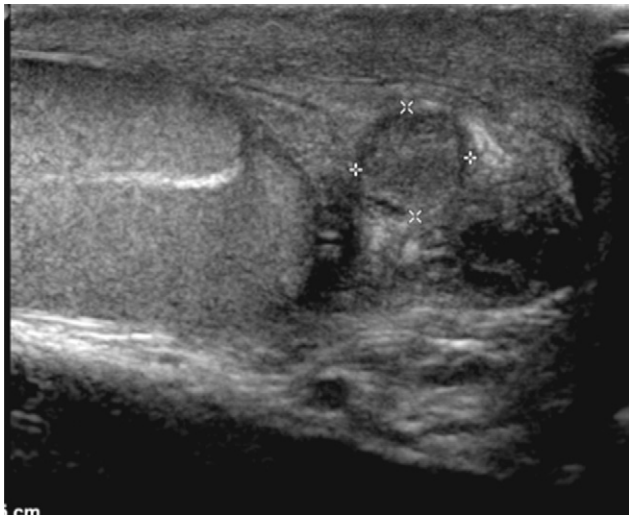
Tuberculous epididymitis. B-mode sonography: nodule of the tail of the epididymis.
